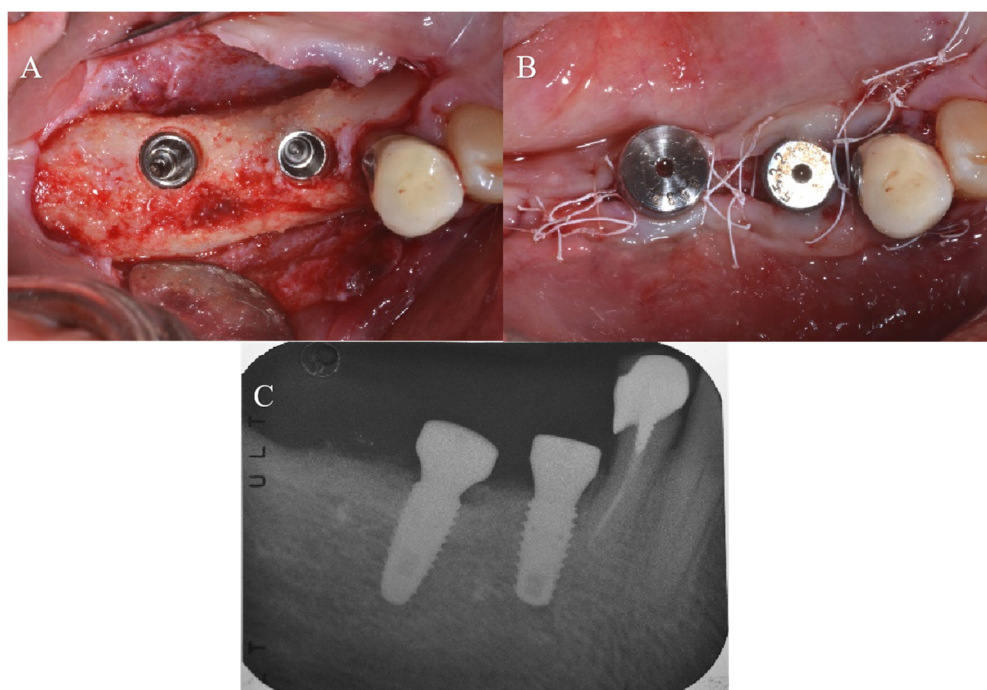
Two implants were inserted in the premolar/molar region 1 mm below the bone crest (A), and healing abutments were applied simultaneously (B). The control periapical radiograph (C).
